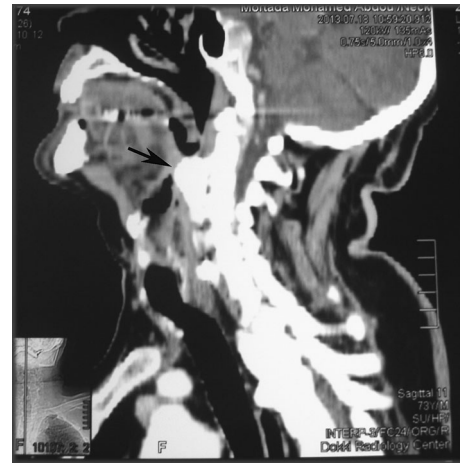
A sagittal computed tomography. The *arrow* points to the hyperostotic anterior longitudinal spinal ligament with large osteophytes compressing the aerodigestive tract
